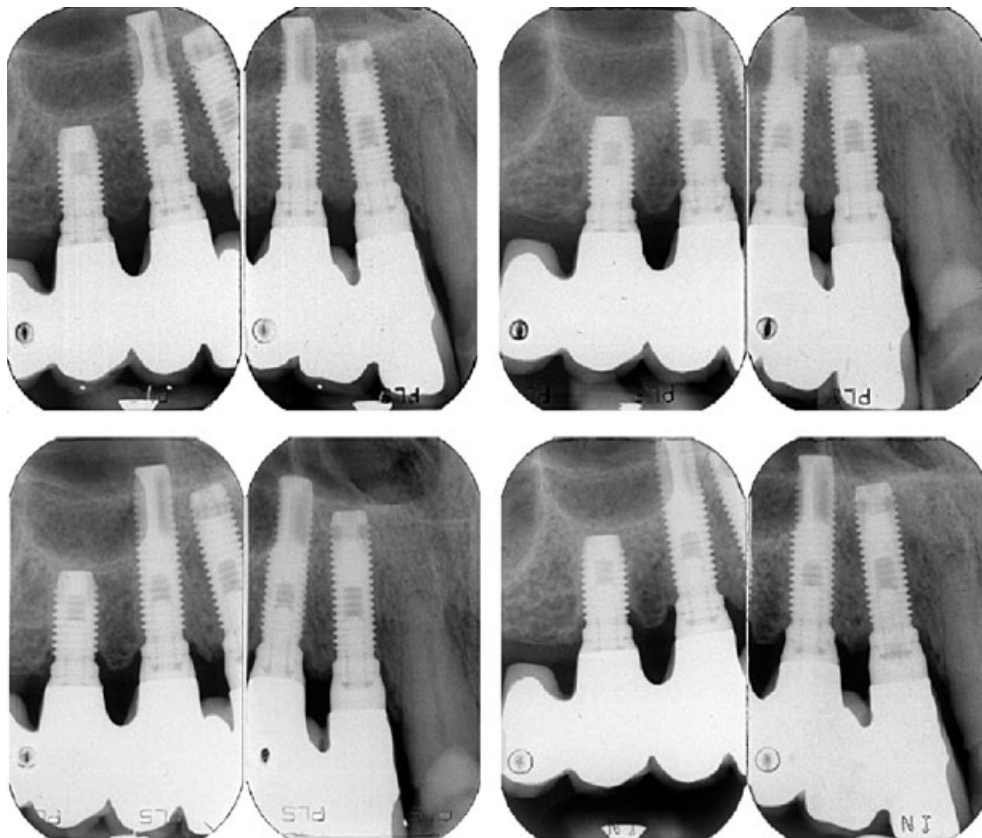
Intraoral radiographs taken with a free-hand technique and by different radiographers at bridge installation (upper left corner) and at follow-up examinations (1, 3, and 5 years later) demonstrate excellent possibilities of monitoring the post-operative course of events.
